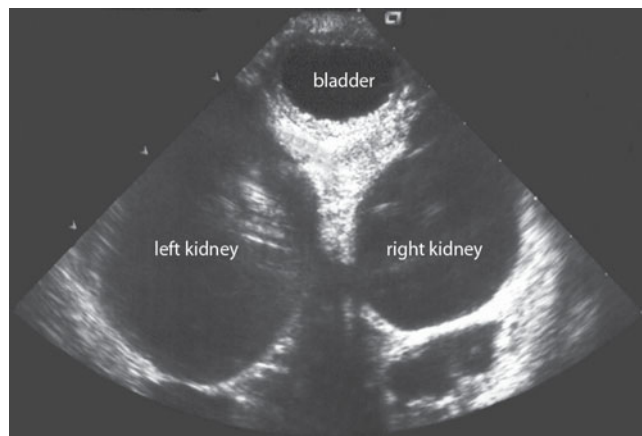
Hydronephrosis. The prenatal sonogram shows marked dilatation of both renal pelvis with no evidence of renal parenchyma
